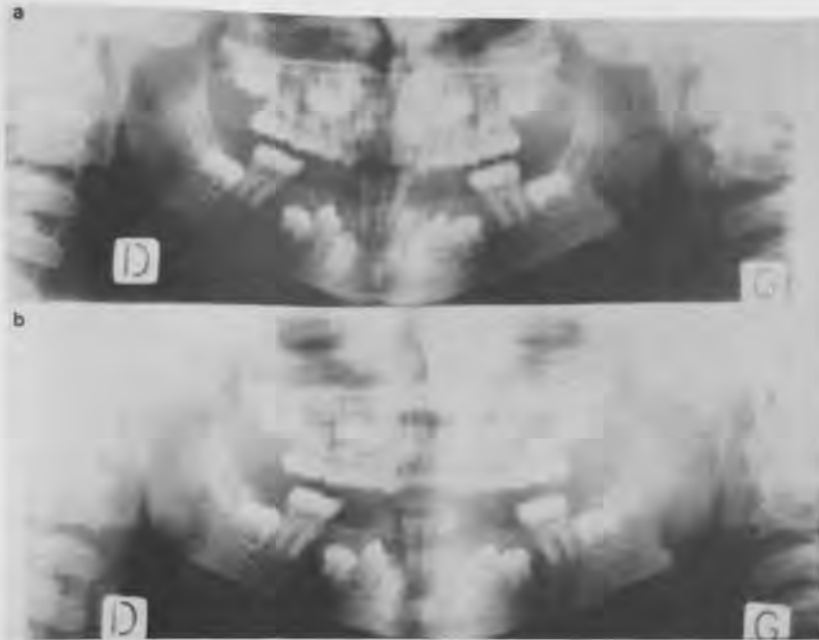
a - oro-dental panoramic radiography immediately after surgical exposure, and...
